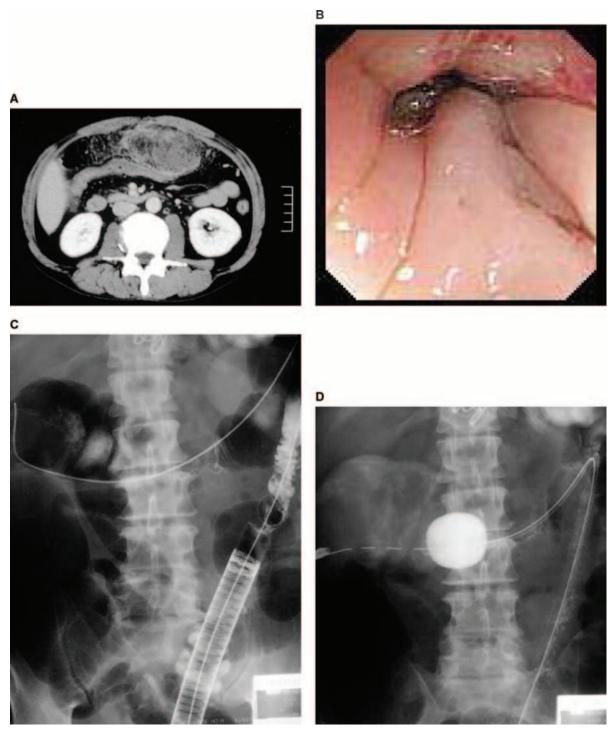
(*A*) CT showing a giant abscess from the great omentum, (*B*) colonoscopy showing postoperative stenosis of the transverse colon, (*C*) radiographic view of a flexible guidewire introduced through the obstruction with the sliding tube (overtube) in place, and (*D*) the DCT was successfully placed for decompression.
